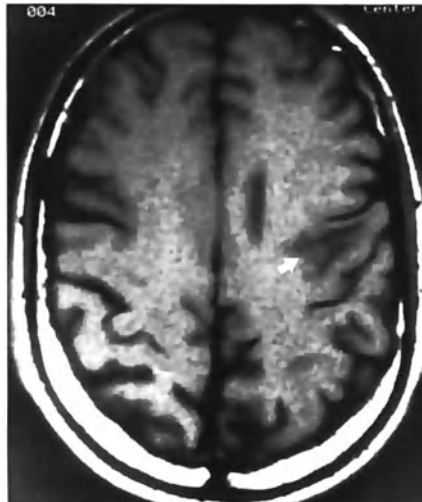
Progressive multifocal leukoencephalopathy.  $T_1$ -weighted MR image shows a solitary lesion at the gray-white junction of the left precentral gyrus without surrounding edema or mass effect. The lesion appeared as a solitary area of hypodensity on contrast-enhanced CT scans (not shown) (TR = 600, TE = 30)
